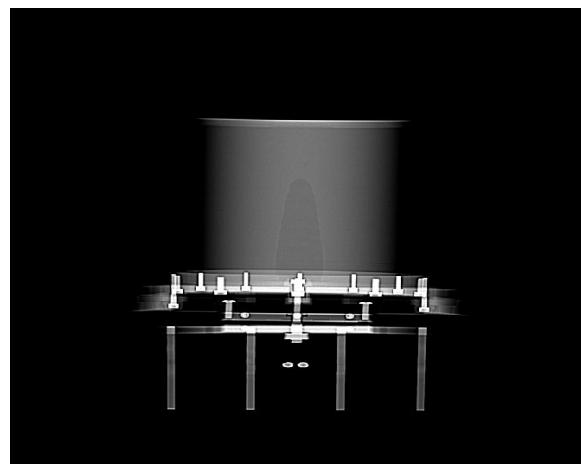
Scout view of CT (Scan time : 3 min)
